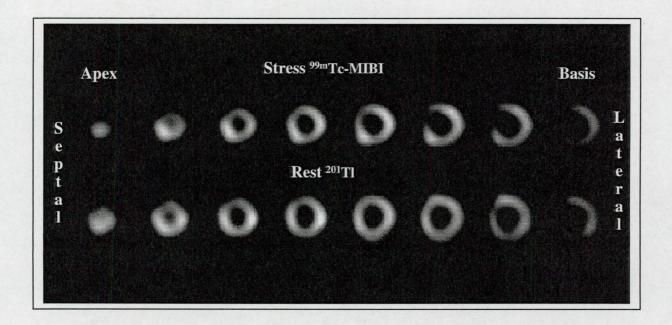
Short-axis SPECT images of a patient with sequential coronary stents in the proximal portion of the LAD. At the time of stent implantation, a significant stenosis developed at the origin of the septal branch artery in this patient. The Tc-MIBI stress images reveal a small area with hypoperfusion in the basal, anteroseptal region. The Tl rest images indicate a normal tracer distribution. Coronary angiography demonstrated no significant restenosis in the region of the implanted stents. The reversible perfusion abnormality on stress scintigraphy corresponds to the stenosis of a side-branch artery.
